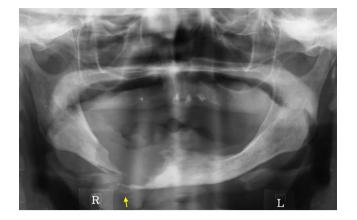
Panoramic radiograph showing ill-defined destructive bone resorption, accompanied by fracture on the right side of the mandible (arrow).
